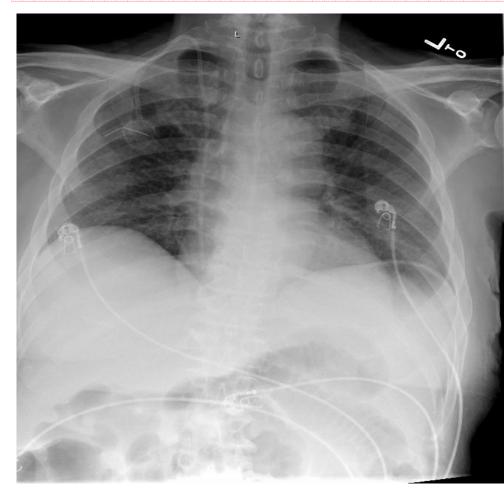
Patient's initial chest x-ray (CXR) obtained on the day of admission which shows a port located in the right chest wall with no focal consolidation, effusion, or infiltrate.
